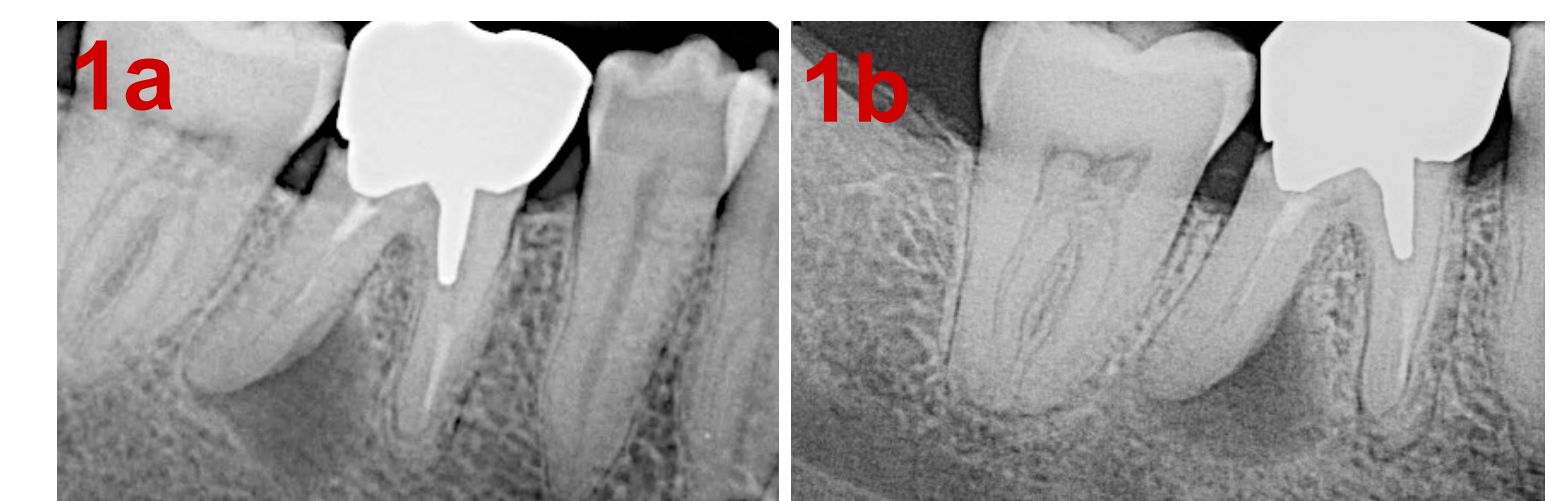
The 46-year-old male with stage II thyroid SCC., receiving a total dose of 66 Gy. The periapical dose to this tooth was 41.7 Gy. Fig. 1b shows the post-XRT dental condition, captured after 2.5 years.
